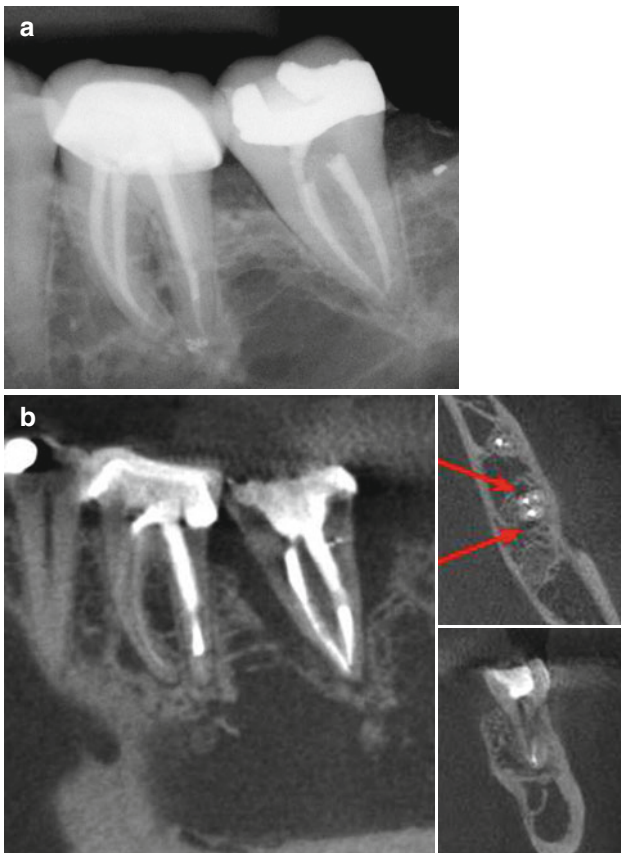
Digital radiography versus cone beam computed tomography. (a) Bony resorptive lesions are not evident. (b) CBCT scans on different planes clearly show the bony defects (Courtesy Dr M. Feldman)
